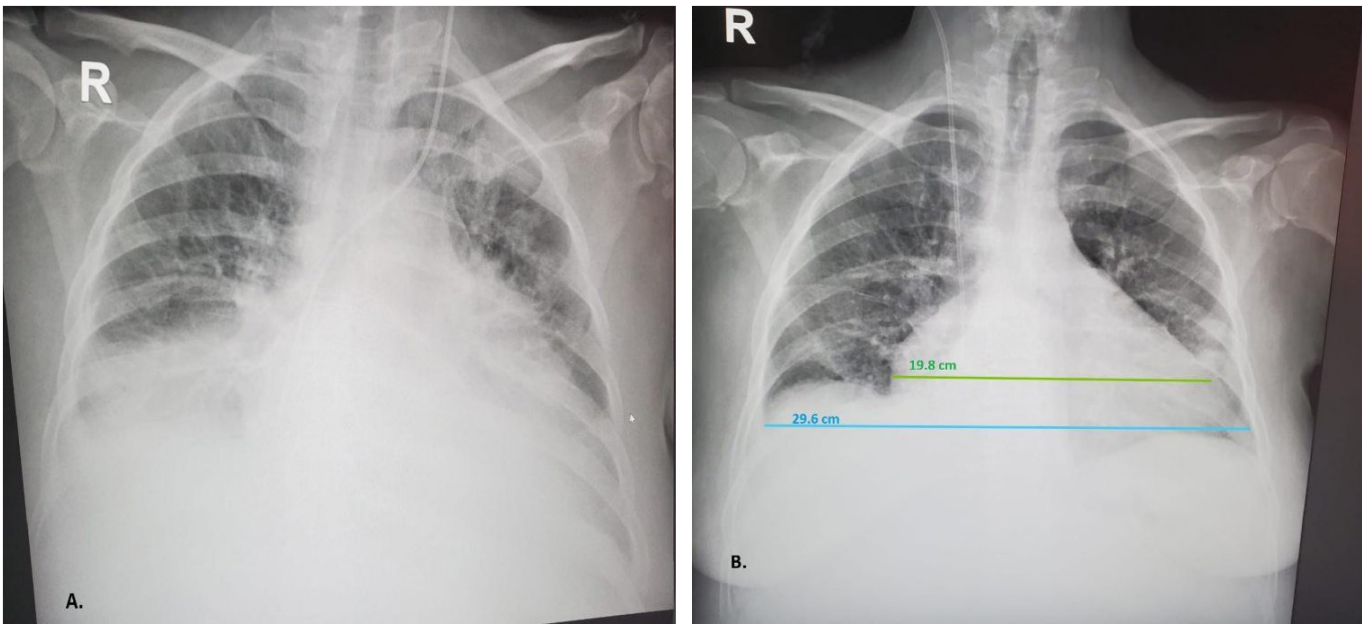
Relevant Chest X-Rays: A (HD 23) - Moderate right pleural effusion, Small left pleural effusion, Pulmonary congestion, Bilateral infiltrates, Central venous catheter (CVC) with the distal tip in the superior vena cava (SVC); B (HD 30): Small left lateral thoracic consolidation. Right costophrenic angle is clear. CVC with the tip in SVC, Cardiomegaly – cardiothoracic ratio>0.5
